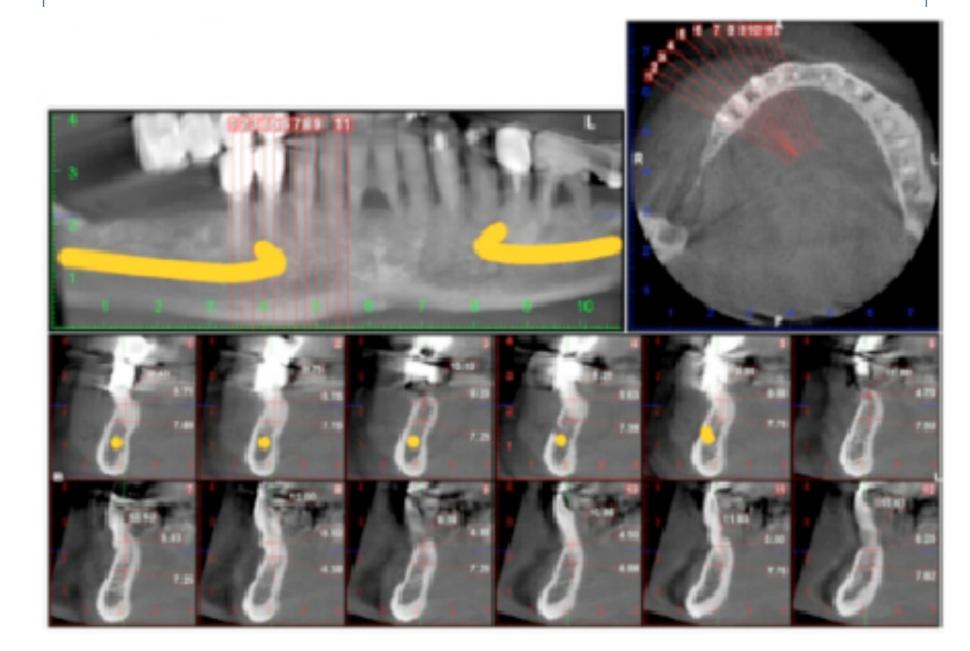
CT image of a mandible in imminence to became full edentulous planned for fixed implants restoration.
